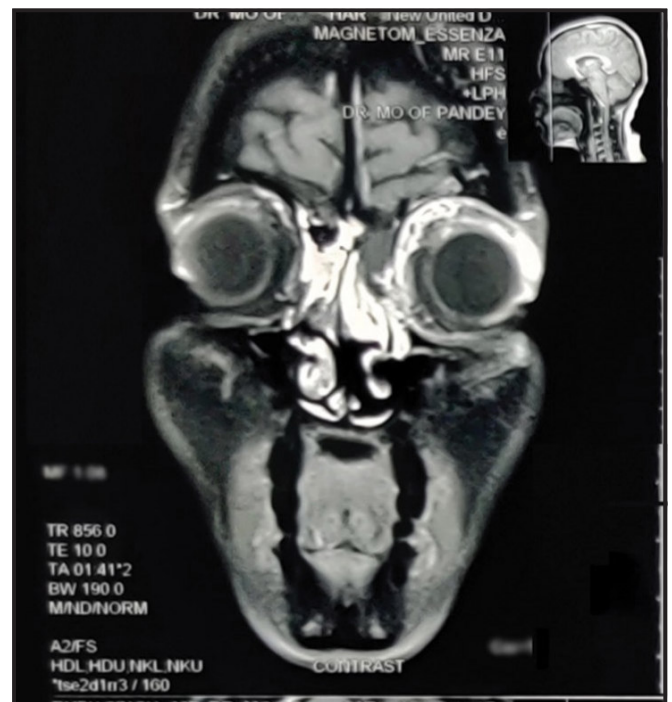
Coronal plane of contrast enhanced T1 weighted MRI shows dark coloured region in the middle turbinate on the left side which shows areas that has not taken up contrast.
